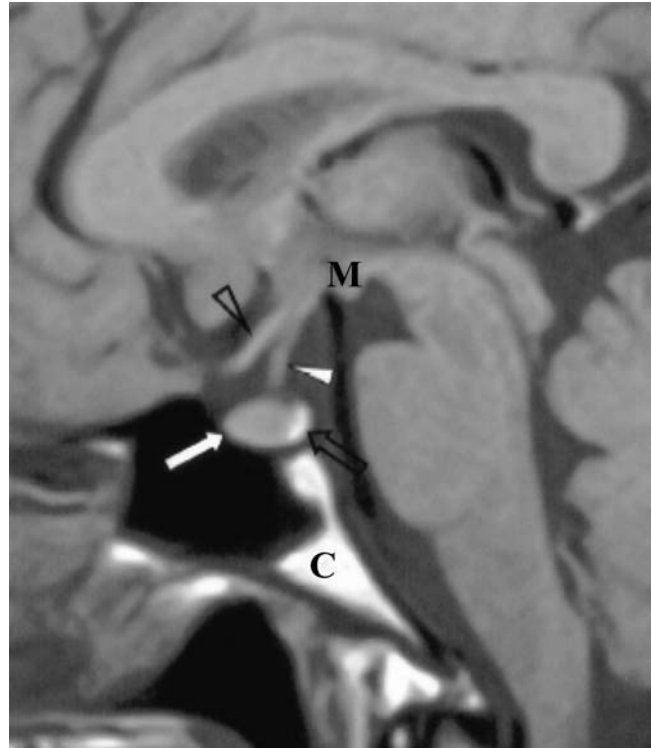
Magnetic resonance image (MRI) appearance of the normal pituitary gland. T1-weighted MRI shows the sagittal view of the normal anatomy of the sella turcica and juxtaseal region. The anterior lobe (thick white arrow), posterior lobe (open arrow), pituitary stalk (thick white arrowhead), optic chiasm (open arrowhead), mammillary body (M), and clivus (C) are indicated. *Source:* From Ref. 157.
